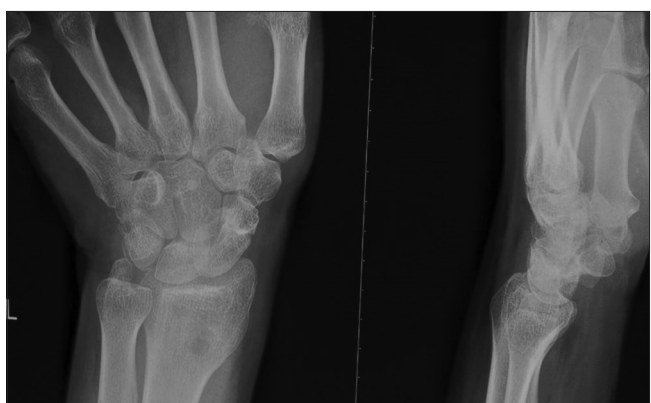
Radiograph at 12 weeks post-operative showing bony union
